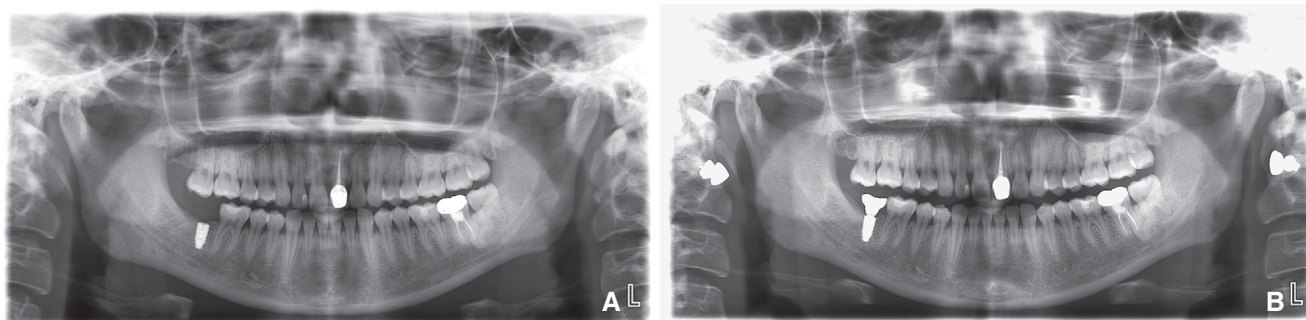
Panoramic radiographs. A, Three months after implant placement. B, At 3-month follow-up visit.
